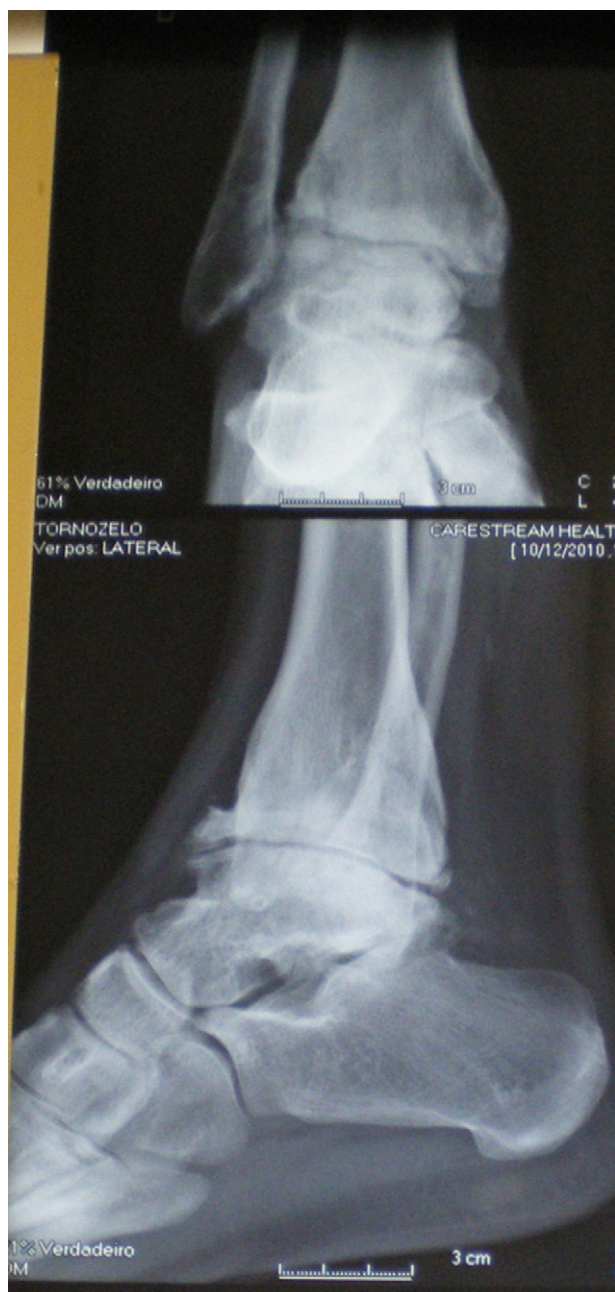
X-ray of the right ankle.
